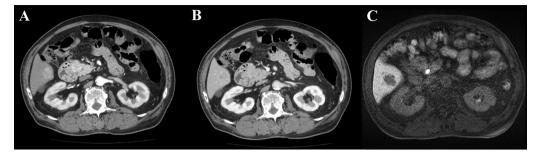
(A, B) Abdominal computed tomography revealed a hypervascular tumor with washout of contrast-medium. A mass located in the right posterior section of the liver. (C) The tumor showed no gadolinium ethoxybenzyl diethylenetriaminepentaacetic acid (Gd-EOB-DTPA) uptake on hepatocyte-phase images obtained by Gd-EOB-DTPA magnetic resonance imaging.
